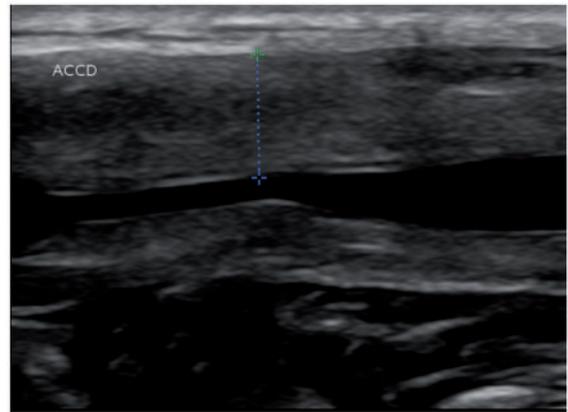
Ultrasound image of a right common carotid artery with typical multilayer thickening of vessel wall in Takayasu disease.
